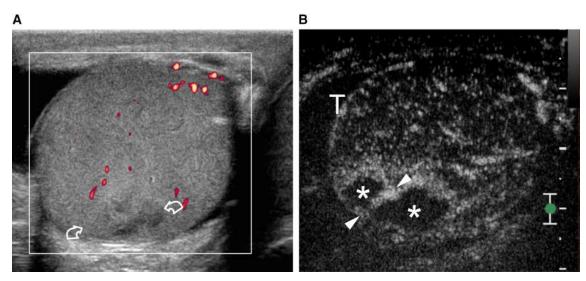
A 52-year-old man with right segmental testicular infarction. A Color Doppler US image shows inhomogeneous lesion (curved arrows) lacking color signals. The testis appears globally hypovascular. B CEUS image shows two
